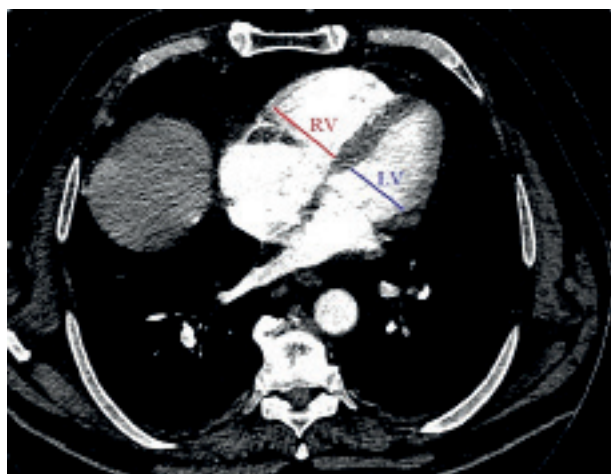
Measurement of right ventricular (RV) and left ventricular (LV) transverse diameters on axial computed tomography pulmonary angiography images used for calculation of the right ventricle/left ventricle ratio. RV and LV diameters were measured at the level of maximal ventricular diameter perpendicular to the long axis of the heart
